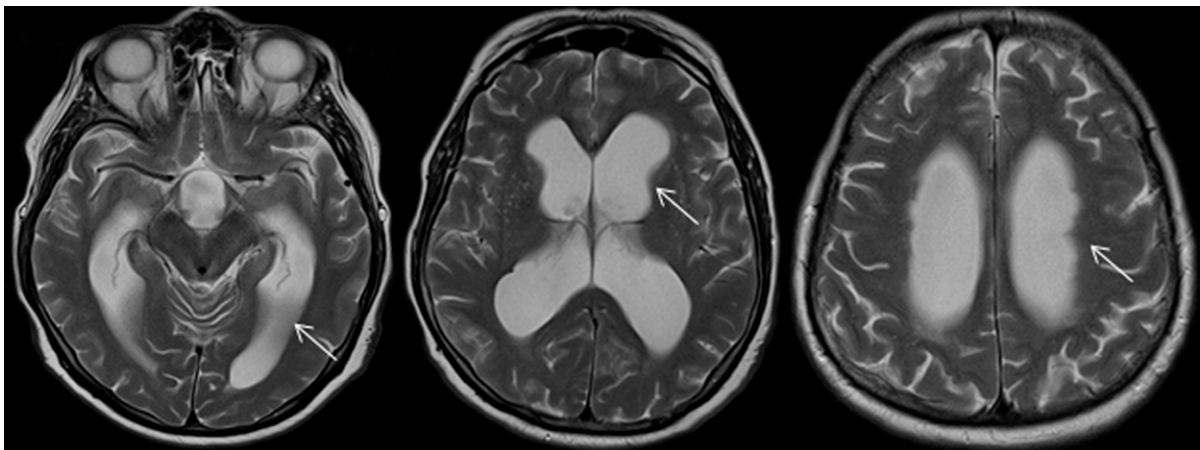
A magnetic resonance imaging (MRI) of the control patient with normal pressure hydrocephalus demonstrating dilated ventricles (white thin arrow)
